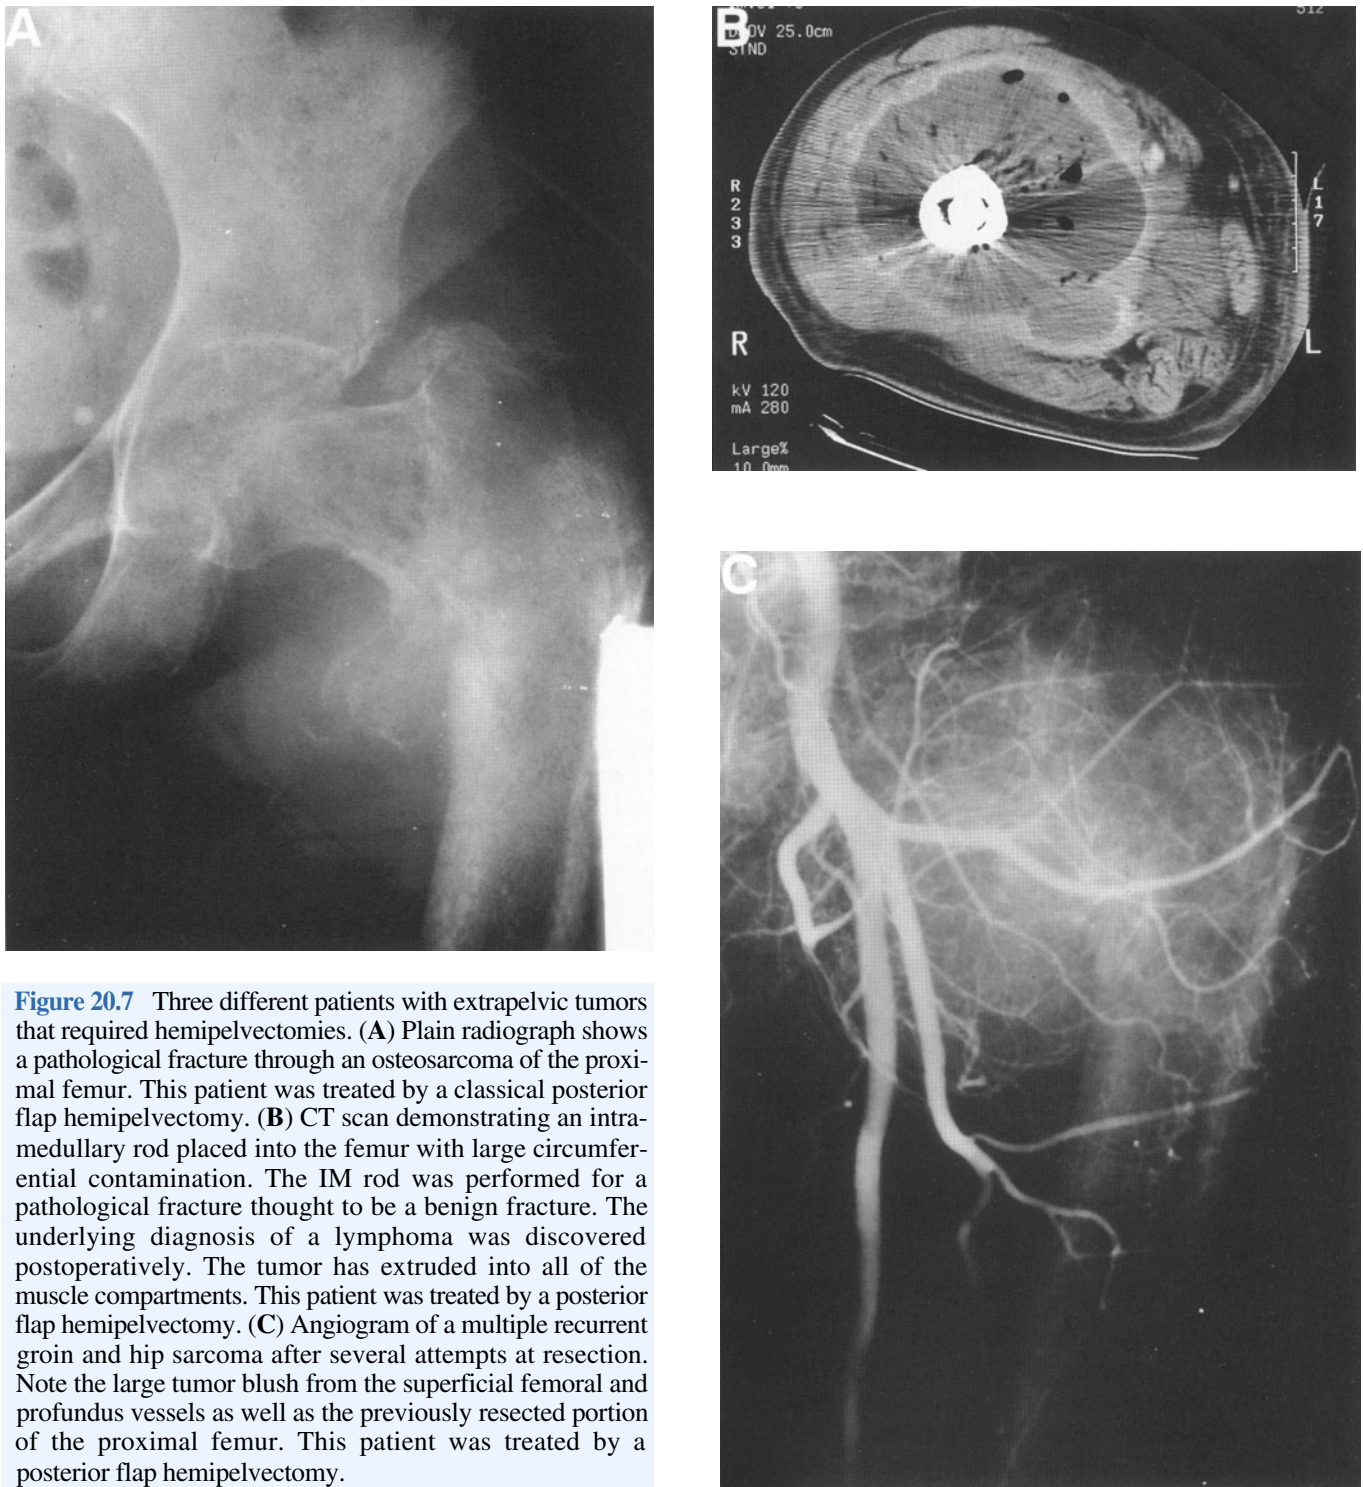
Three different patients with extrapelvic tumors that required hemipelvectomies. (A) Plain radiograph shows a pathological fracture through an osteosarcoma of the proximal femur. This patient was treated by a classical posterior flap hemipelvectomy. (B) CT scan demonstrating an intramedullary rod placed into the femur with large circumferential contamination. The IM rod was performed for a pathological fracture thought to be a benign fracture. The underlying diagnosis of a lymphoma was discovered postoperatively. The tumor has extruded into all of the muscle compartments. This patient was treated by a posterior flap hemipelvectomy. (C) Angiogram of a multiple recurrent groin and hip sarcoma after several attempts at resection. Note the large tumor blush from the superficial femoral and profundus vessels as well as the previously resected portion of the proximal femur. This patient was treated by a posterior flap hemipelvectomy.
